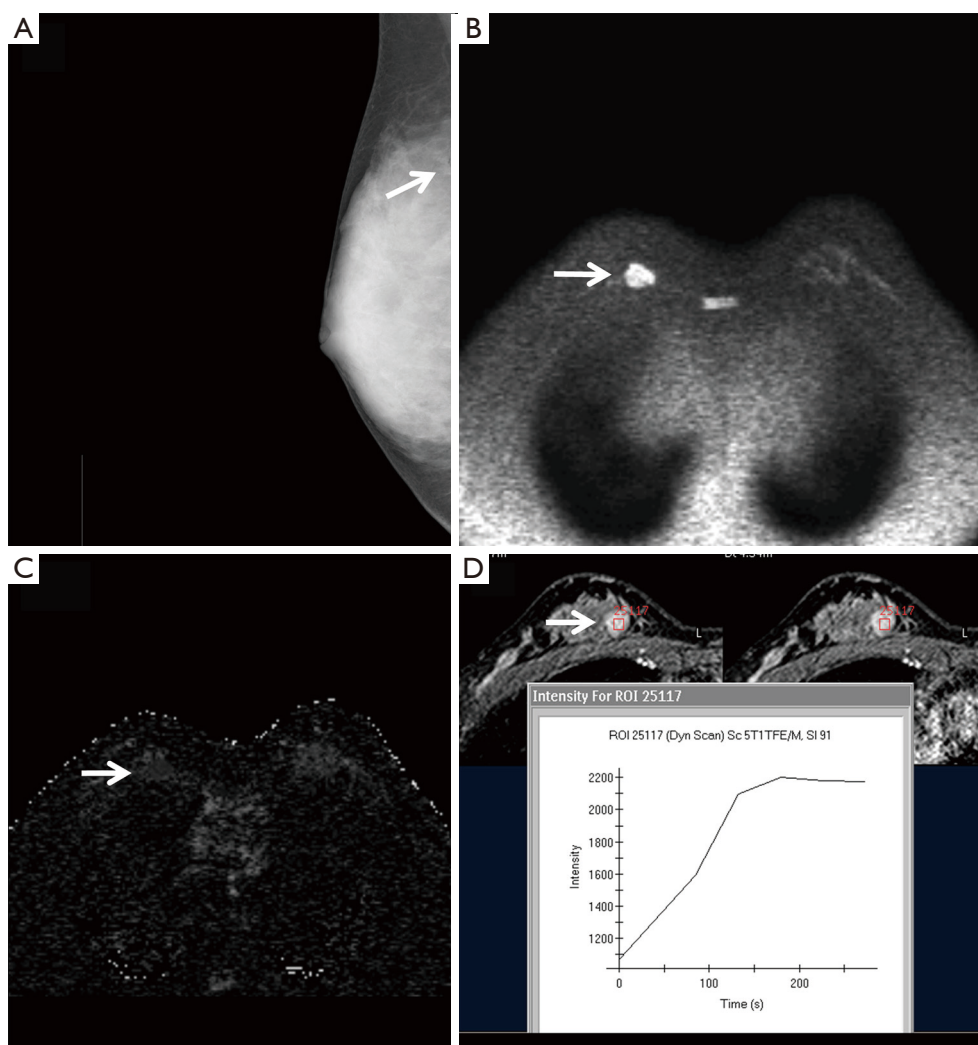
A 34-year-old female patient with right breast invasive ductal carcinoma. (A) Craniocaudal view of the FFDM with an architectural distortion in the inner upper region of the right breast that was in BI-RADS category 3 by mammography (arrow); (B) MRI diffuse axial view with a nodular DWI high-signal-intensity opacity in the inner upper region of the right breast (arrow); (C) MRI diffuse axial view, with the lesion ADC showing a significantly low signal (arrow); (D) significant enhancement of the lesion, with the TIC curve being flat. FFDM, full-field digital mammography; BI-RADS, breast imaging reporting and data system; TIC, time-intensity curve.
